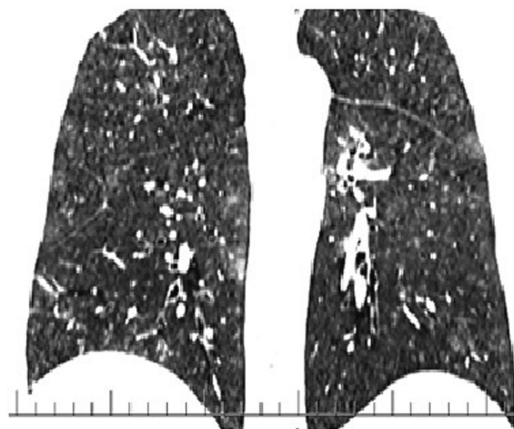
CT chest of patient with nasal liquor rhea. (Ground glass appearances are present).
